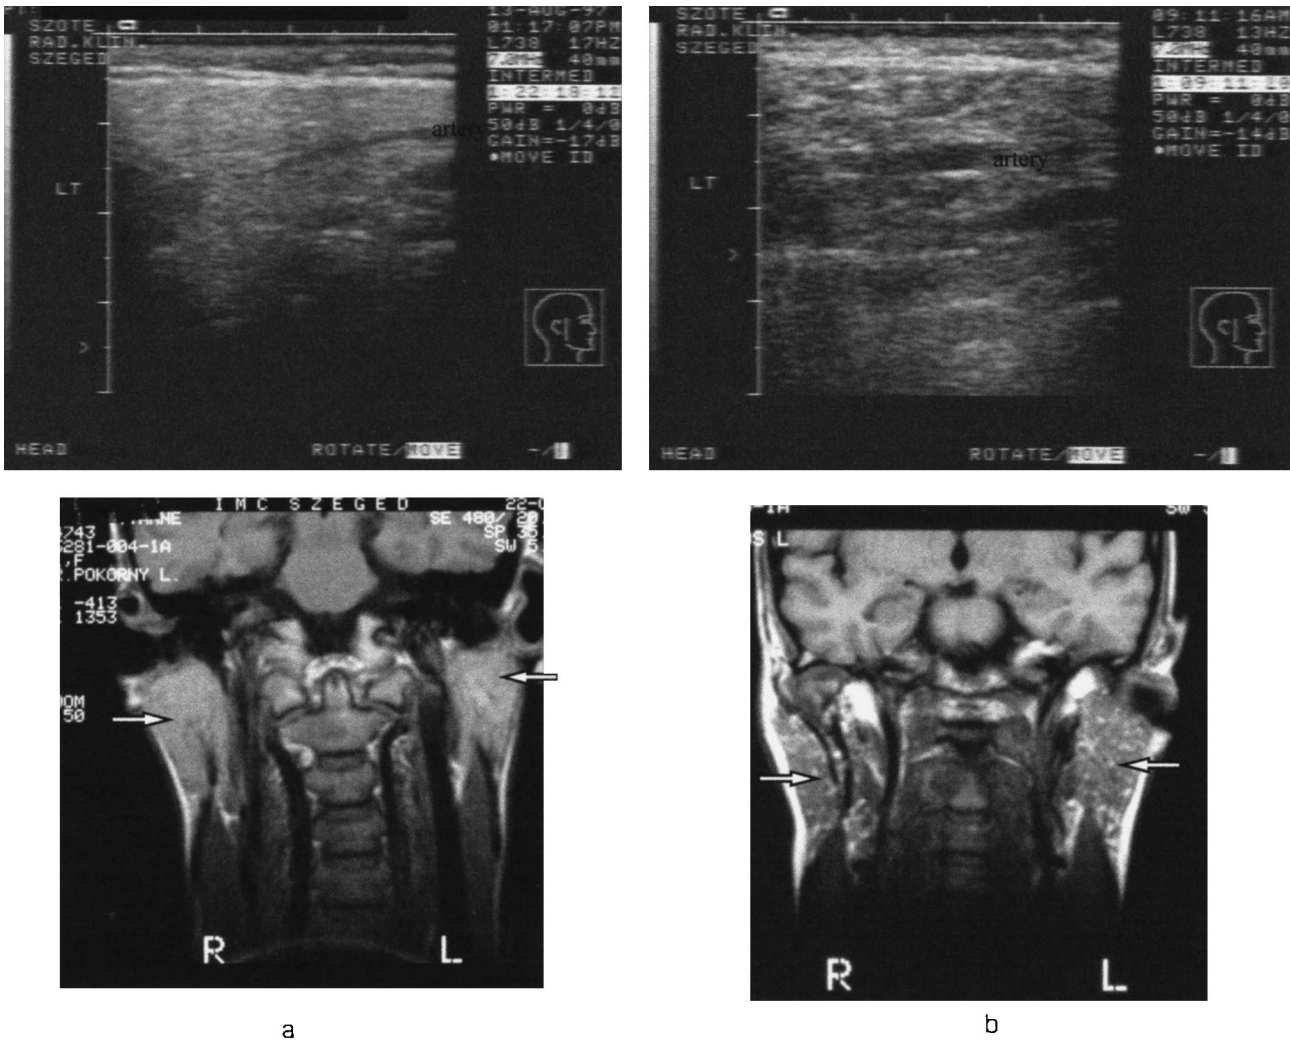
Parenchymal patterns of the parotid glands on US and MRI examinations in patients with SS. (a) Homogeneous parotid in a 47-yr-old SS patient on US (upper) and MRI (lower) examinations. (b) Gross PIH in the parotids on US, and a coarsely nodular pattern on MRI examination in a 46-yr-old SS patient.
